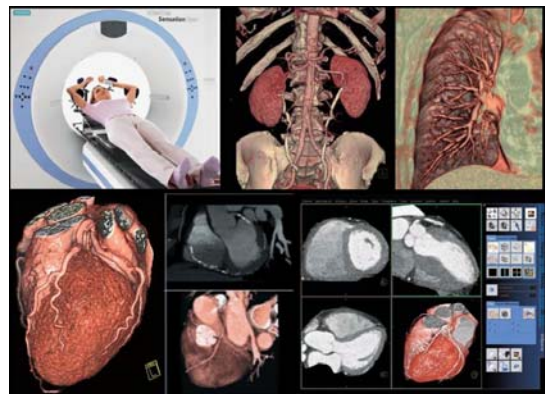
Modern imaging system – a 64 row helical CT scanner – and examples of 3D and 4D volume rendered images.
